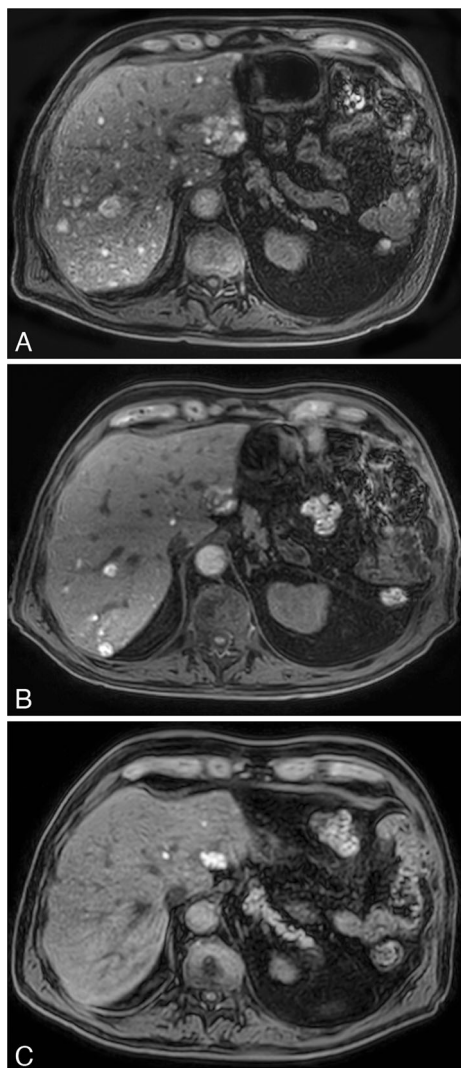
A Baseline MRI of a 74-year-old patient with metachronous bilobar liver metastases from uveal melanoma, showing hyperintense multiple metastases in both liver lobes on the unenhanced images. The patient was treated with 2 courses of M-PHP together with IPI/NIVO 1 mg/kg each. In panel B, follow-up MRI shows partial response of baseline lesions. In panel C, 2 years and 3 months after baseline imaging, most lesions disappeared indicating sustained partial response. Yet, CT of the chest (not shown) demonstrated a new metastasis of the sixth rib on the right side consistent with progressive disease
